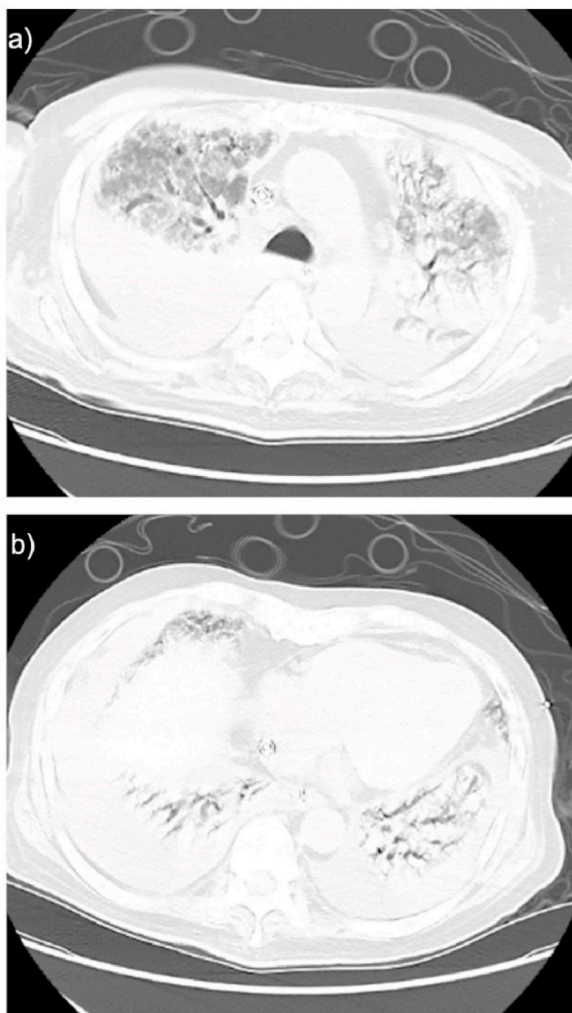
a) Chest CT scan showing ground-glass opacity, air bronchogram, patchy consolidation in the bilateral upper lobes, bilateral pleural effusion, and the ECMO catheter in the SVC. b) Chest CT scan demonstrating atelectasis, organizing, bilateral air bronchogram, and the ECMO catheter in the RA.
